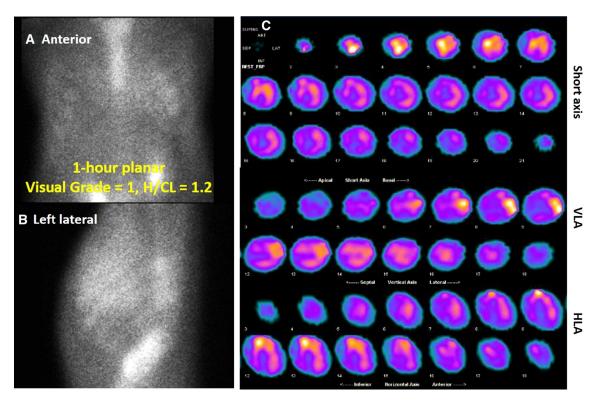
Confirmation of myocardial uptake by Pyrophosphate SPECT in a patient with a Perugini Score of 1. Anterior (\mathbf{A}) and left lateral (\mathbf{B}) planar images demonstrating mild PYP uptake, which was confirmed on PYP SPECT (\mathbf{C}).
